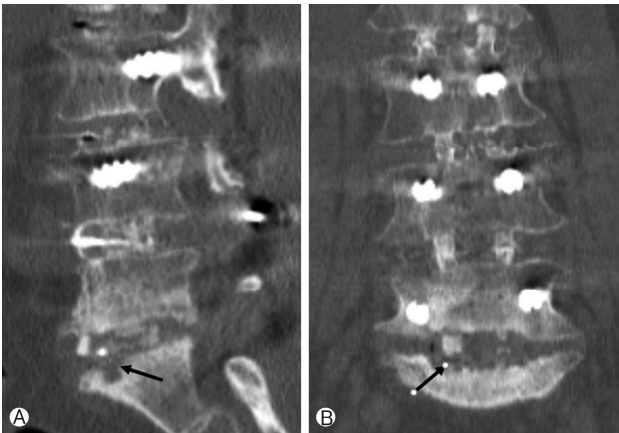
72-year-old female underwent L2-3-4-5-S1 posterior lumbar interbody fusion with rhBMP-2 (Bio-BMP2) applied to the top and bottom surfaces of the interbody cage. At postoperatively 12 months, CT scan showing low endplate erosions at L5-S1 level. During follow up, she presented continuous back pain, thus revision surgery was required. Rh-BMP2; recombinant human bone morphogenetic protein-2.
